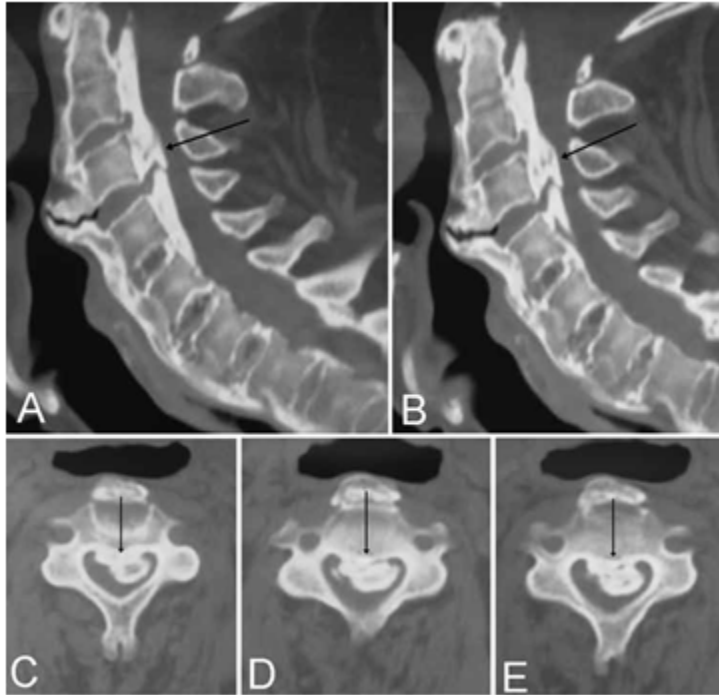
Computed tomography scans showing OPLL in different locations.
